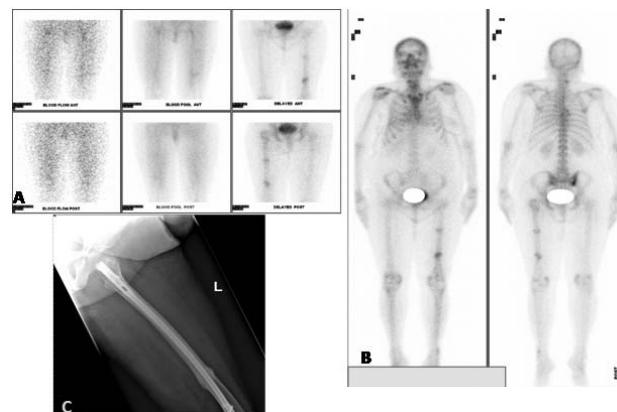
Dynamic ^{99m}Tc MDP bone scintigraphy showing two active osteoblastic lesions in left femur involving both cortices in a patient with complete internally fixed left femoral shaft fracture. (C) Internally fixed left distal femur fracture with persistent fracture line and cortical thickening (delayed union) and no morphological abnormality in proximal femur as noted on bone scintigraphy (likely new evolving insufficiency fracture).
